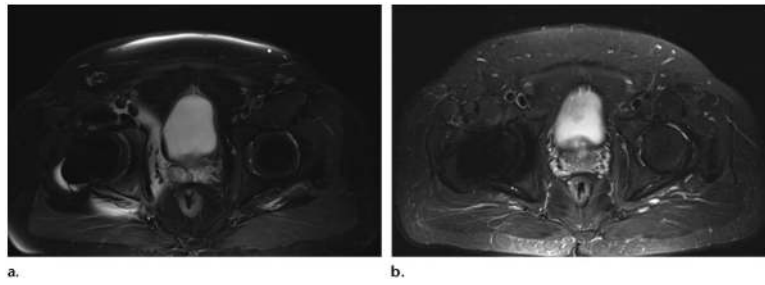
Axial T2-weighted SPAIR fat-suppressed (TR, 4000 msec; TE, 74 msec) (a) and STIR (TR, 3970 msec; TE, 54 msec; TI, 220 msec) (b) MR images show that susceptibility artifacts from metal hip implants are more pronounced on SPAIR images, which are B_0 sensitive, than they are on STIR images, which are not.
